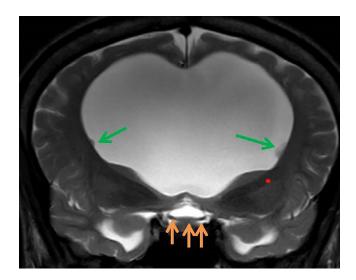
Magnetic resonance imaging of the brain T2 weighted imaging coronal section shows hypoplastic optic chiasm (orange arrows). Subependymal nodules noted (green arrows).
